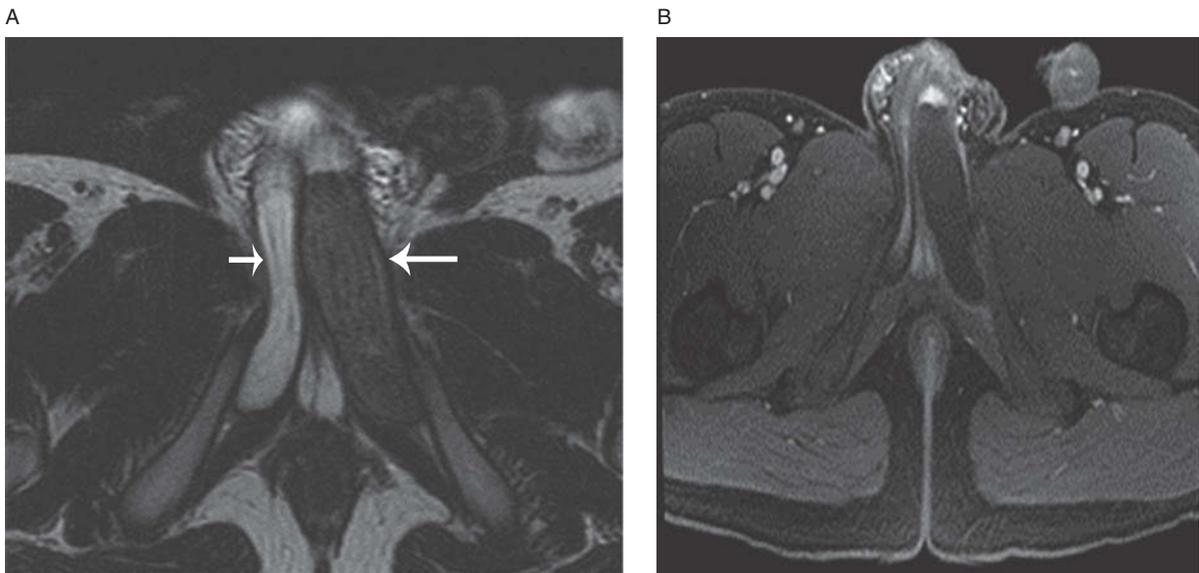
Cavernal thrombosis in a 25-year-old male. Axial T2-weighted image (A) shows diffuse decreased signal intensity and enlargement of the left corpora cavernosa (long arrow) compared to the normal right corpora cavernosa (short arrow). Axial contrast-enhanced T1-weighted image with fat saturation (B) shows corresponding lack of enhancement of the left corpora cavernosa. There is normal enhancement of the right corpora cavernosa.
